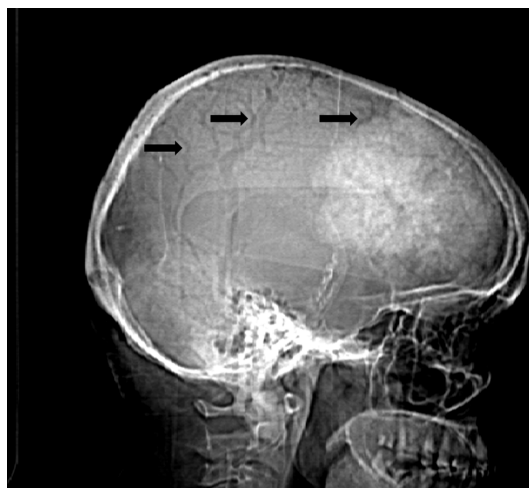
Lateral skull X-ray showing large frontal hyperdense mass with evidence of enlarged meningeal artery grooves (arrows).
